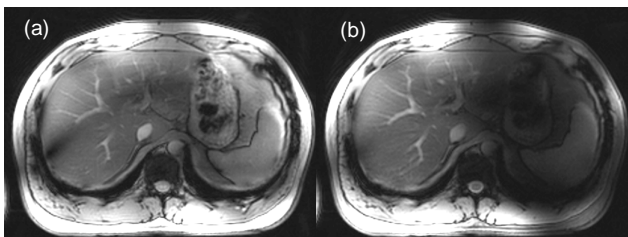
T1-weighted FLASH image, in-phase, breath hold. (a) Circularly-polarized mode (phase shift 45°) of a flexible body array; (b) shim optimized for B_1^+ homogeneity in the right body region.
